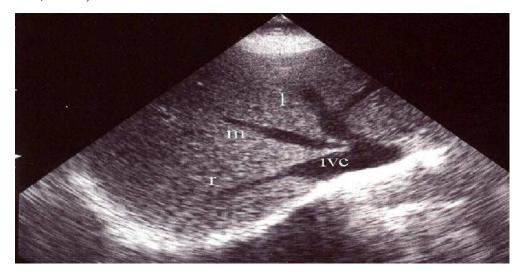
Transverse sonogram of the three main hepatic veins, the right (r), middle (m) and left (l), inferior vena cava (ivc).(Steven,2011)
